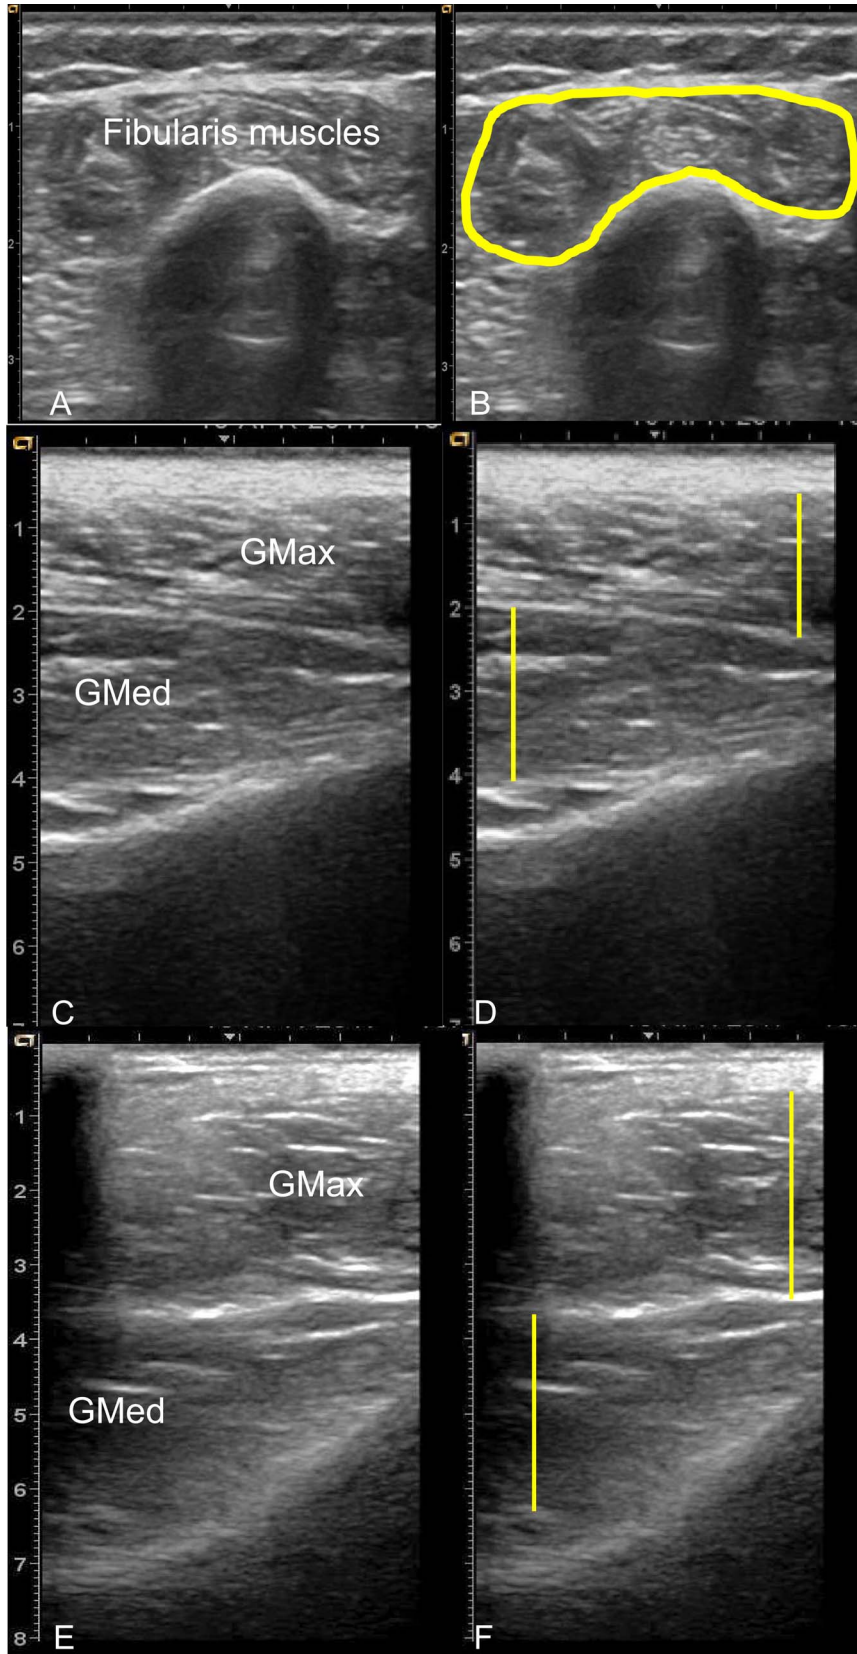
Ultrasound images for the fibularis and gluteal muscles and the corresponding measurement technique. A, Reference image. B, Cross-sectional area measurement. C, Tabletop reference image. D, Thickness measurement. E, Standing reference image. F, Thickness measurement. Abbreviations: GMax, gluteus maximus; GMed, gluteus medius.
